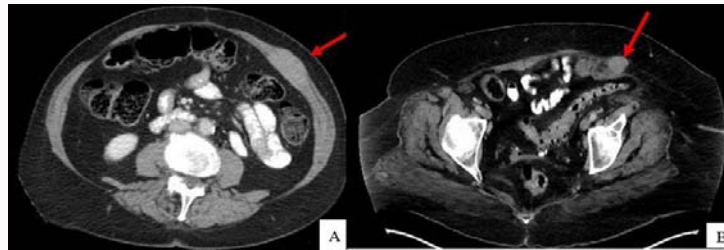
Pre-operative radiographic studies of port-site metastasis. (1A). Case 1, computed tomography of abdomen and pelvis with intravenous and oral contrast showing a 4.5 centimeter left abdominal wall metastatic implant, (1B). Case 2, computed tomography of abdomen and pelvis with intravenous contrast showing a left abdominal wall metastatic implant.
